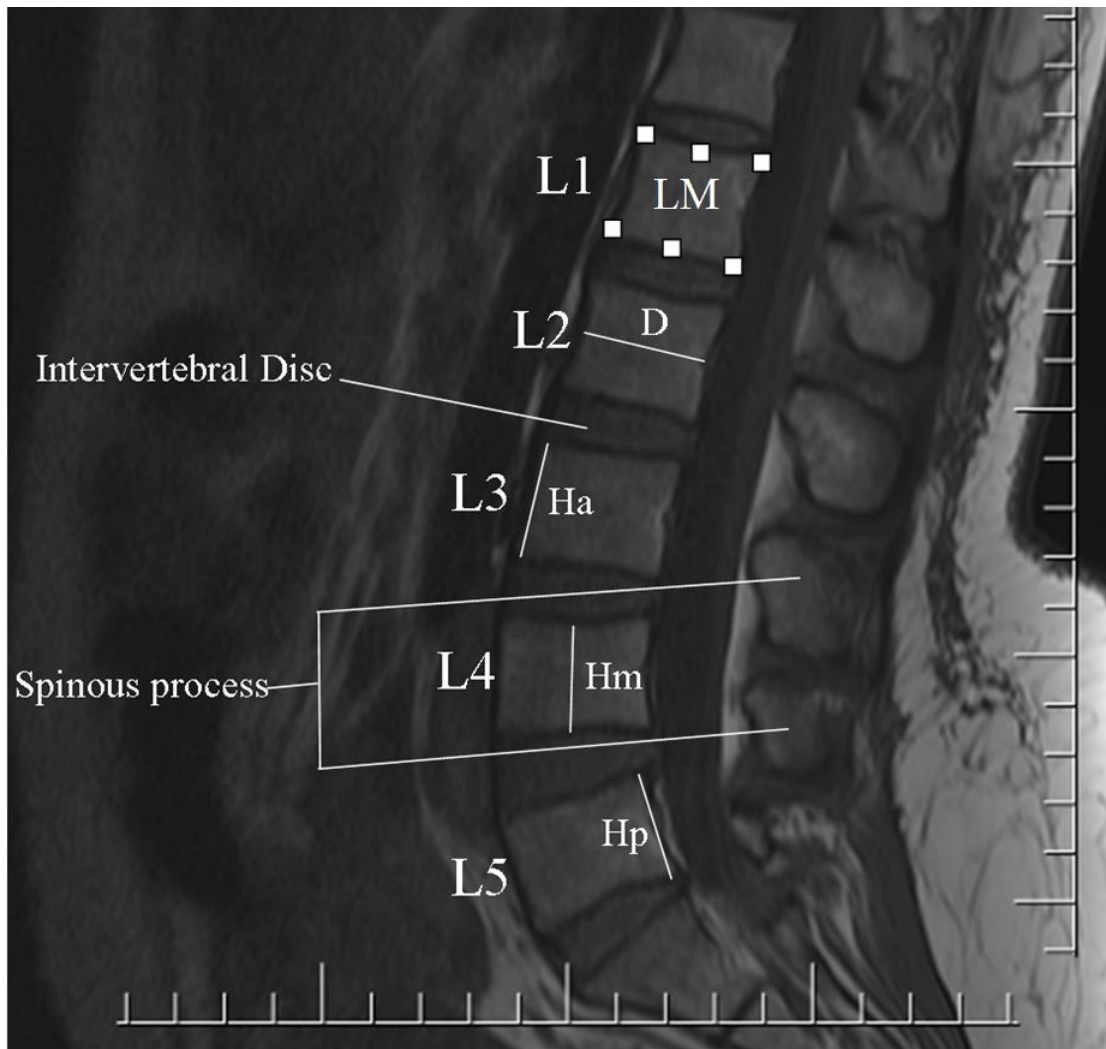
Mid sagittal MRI image of the lumbar spine showing D = anteroposterior diameter, Ha = anterior height, Hp = posterior height and Hm = mid height of the vertebral body. LM represents the six anatomical landmarks that will be used to determine the demarcations for all morphometric measurements. L1-L5 represents the various vertebral levels. Magnification: 0.64 X
